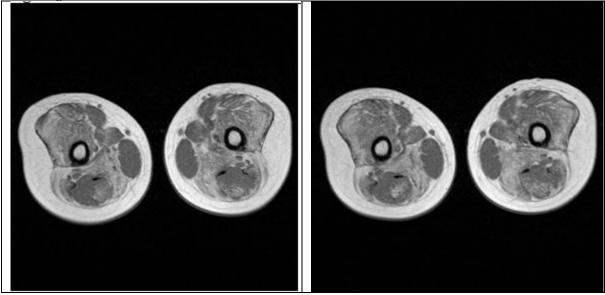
Axial STIR MRI showing early fibrosis and edema in hamstring muscles.
